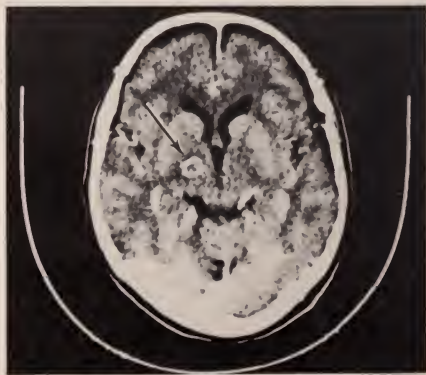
Contrast-enhanced CT scan demonstrating ring-enhancing lesion in the right subthalamic nucleus (arrow).
